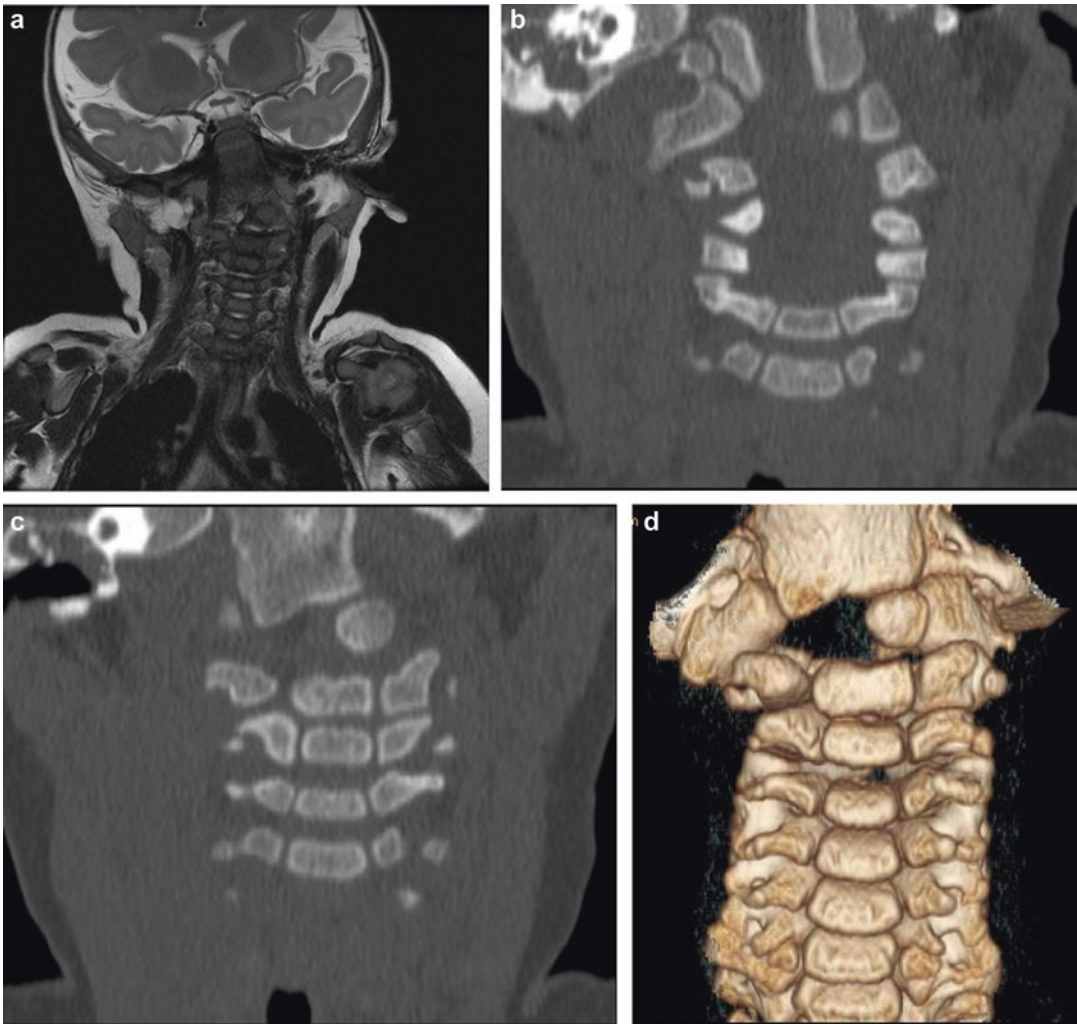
(a–d) 6-month-old male presented with left-sided torticollis. (a) Coronal T2 FRFSE image from MRI of the cervical spine shows leftward torticollis with suspected osseous anomalies at the craniocervical junction and upper cervical spine. (b–d) Subsequently obtained
